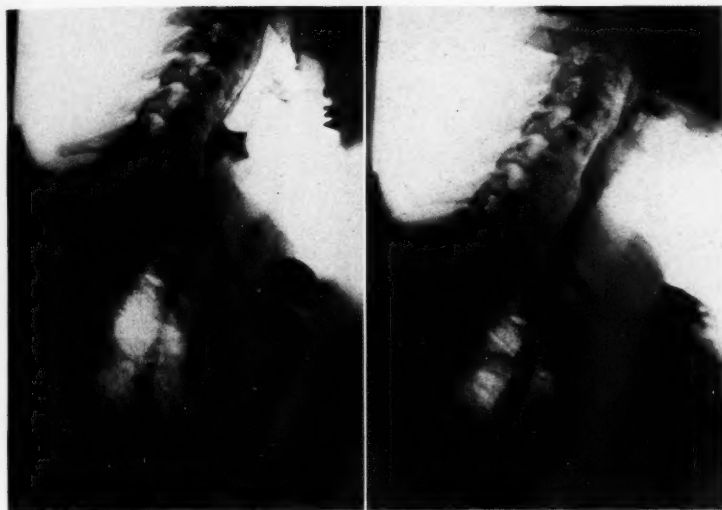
Diverticulum, before and after removal. (Patient is a male, aged 58.) Surgical extirpation through the neck by Dr. Thomas A. Shallow and Dr. Louis H. Clerf. Post-operative roentgen study done during convalescence, before complete recovery.
